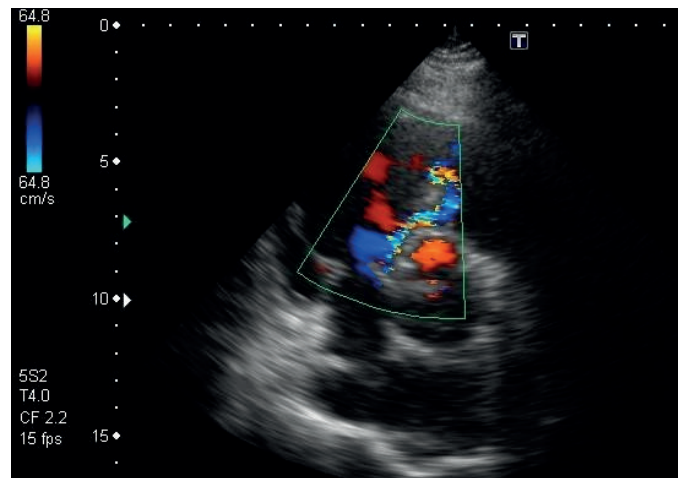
Echocardiography. Parasternal short-axis view. Color Doppler echocardiography of the turbulent flow
